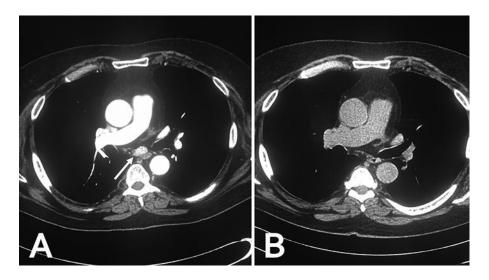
Chest CT scans showed a hilar lymph node prior to the EBUS FNA (A) (arrow) and resolution of the hilar lymph node 5 weeks after the EBUS FNA (B).
